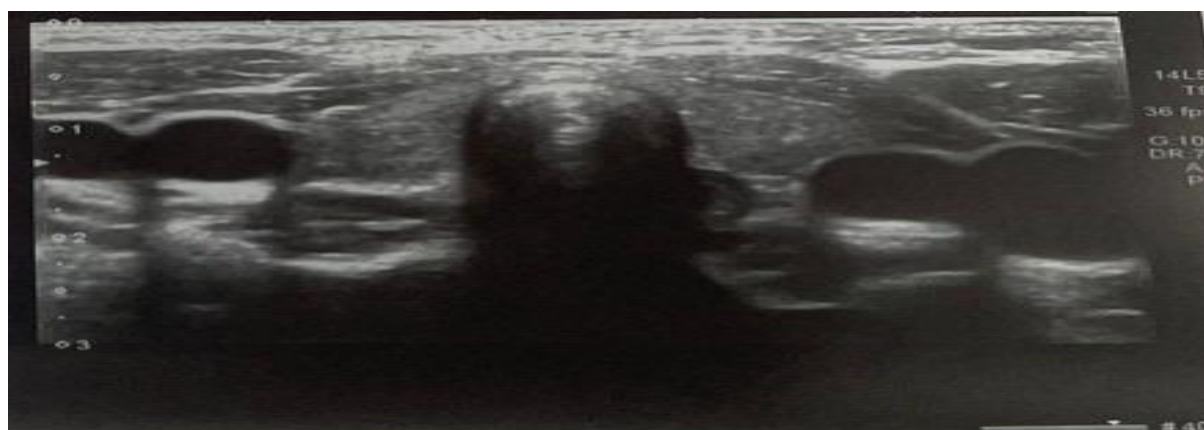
Ultrasound image of the thyroid gland
